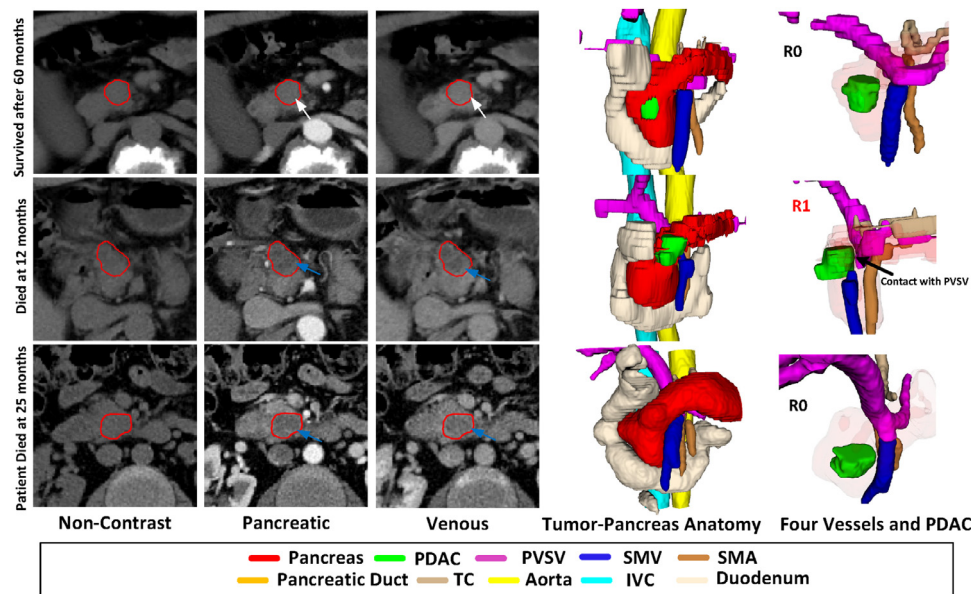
Example of the multi-phase CE-CT images, anatomy segmentation and PDAC tumor enhancement patterns. The blue arrow depicts a hypo-attenuating tumor; white arrow indicates an iso-attenuating mass. The proposed pancreas and peripancreatic anatomy segmentation has 10-class labels. PVSU is short for “Portal Vein and Splenic Vein”, “SMV” for “Superior Mesenteric Vein”, “SMA” for “Superior Mesenteric Artery”, “TC” for “Truncus Coeliacus”, “IVC” for “Inferior Vena Cava”. (For interpretation of the references to colour in this figure legend, the reader is referred to the web version of this article.)
